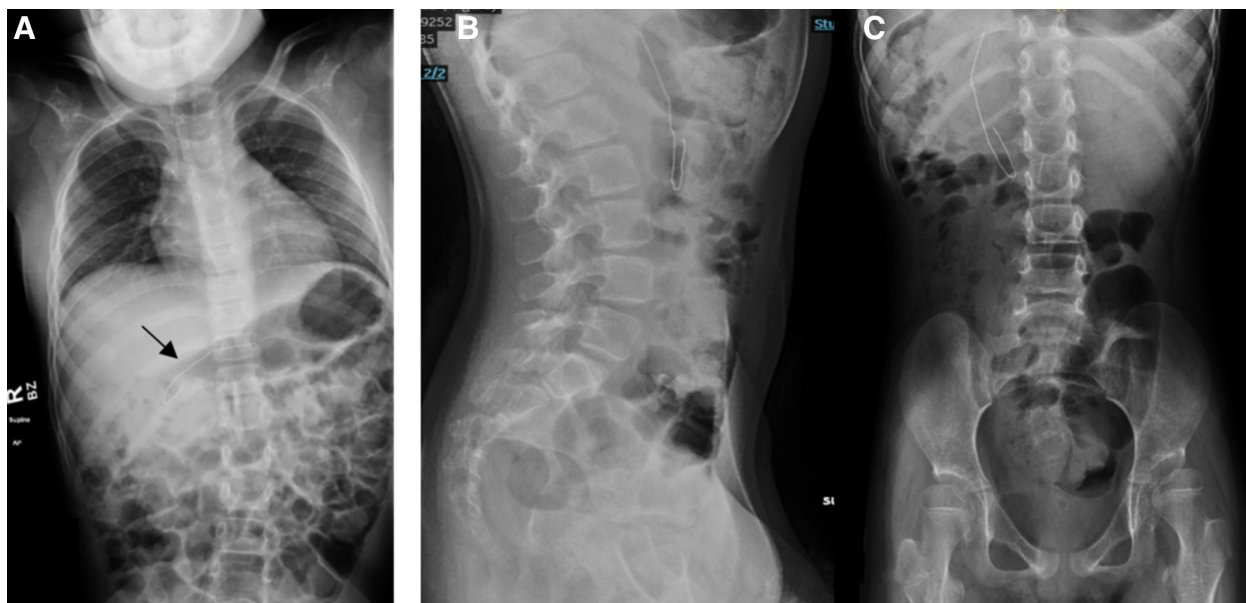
Initial film - metal strip of face mask (arrow) lodged at the pylorus 1 hour after ingestion on the frontal chest and abdominal x-ray (A). Metal strip remained in D2, 18 hours after ingestion on (B) anteroposterior (AP) and (C) lateral abdominal x-rays.
